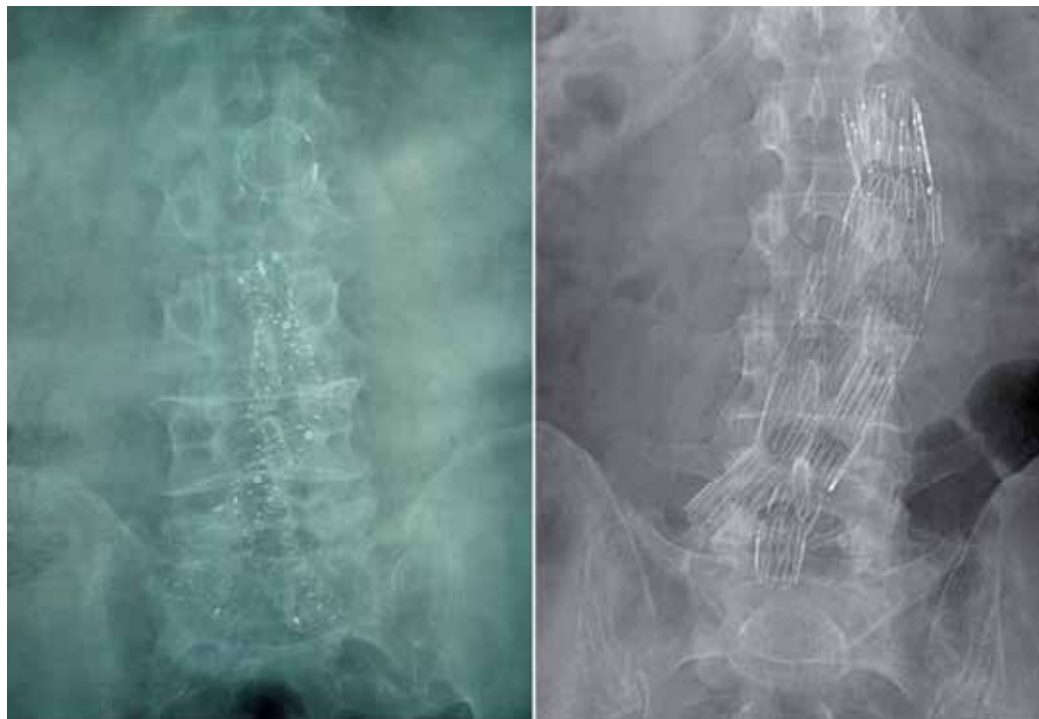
Plain abdominal x-ray. Left: Anaconda bifurcated endoprosthesis (Vascutek Inc., a Terumo Company, Renfrewshire, Scotland, UK). Right: Zenith bifurcated endoprosthesis (Cook Medical Inc., Bloomington, Ind).
